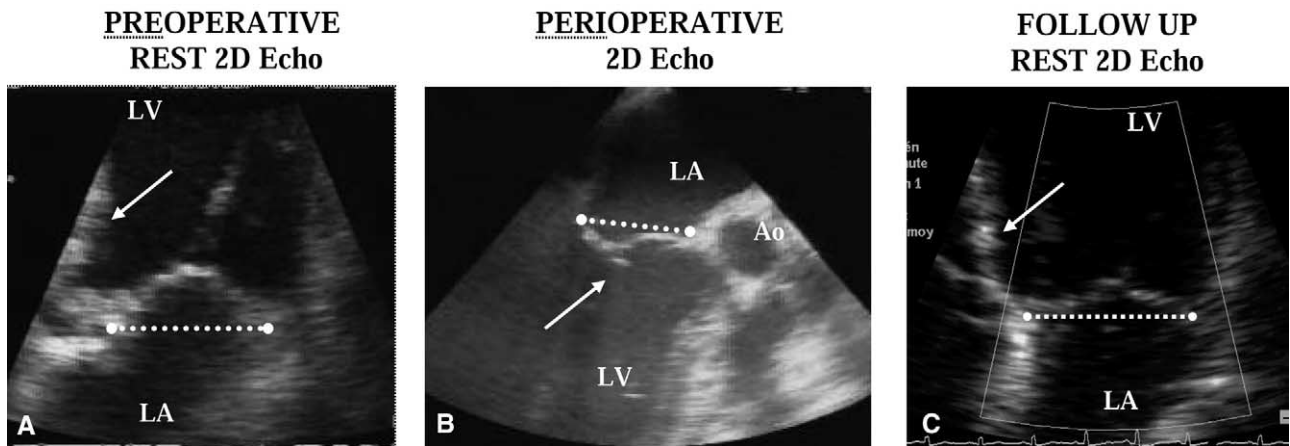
A, Preoperative 2-dimensional echocardiographic analysis. Anterior leaflet angulation at the basal chord insertion, mild bulging of the ischemic inferior wall (arrow) with apical tenting relative to the annulus (dashes), and bent anterior leaflet base. B, Perioperative 2-dimensional echocardiographic analysis. Basal chordal cutting (arrow) and improved coaptation (dashes). C, Follow-up 2-dimensional echocardiographic analysis. Normal mitral coaptation at baseline without anterior leaflet bend despite important left ventricular dilatation (arrow). LV, Left ventricle. LA, left atrium.
